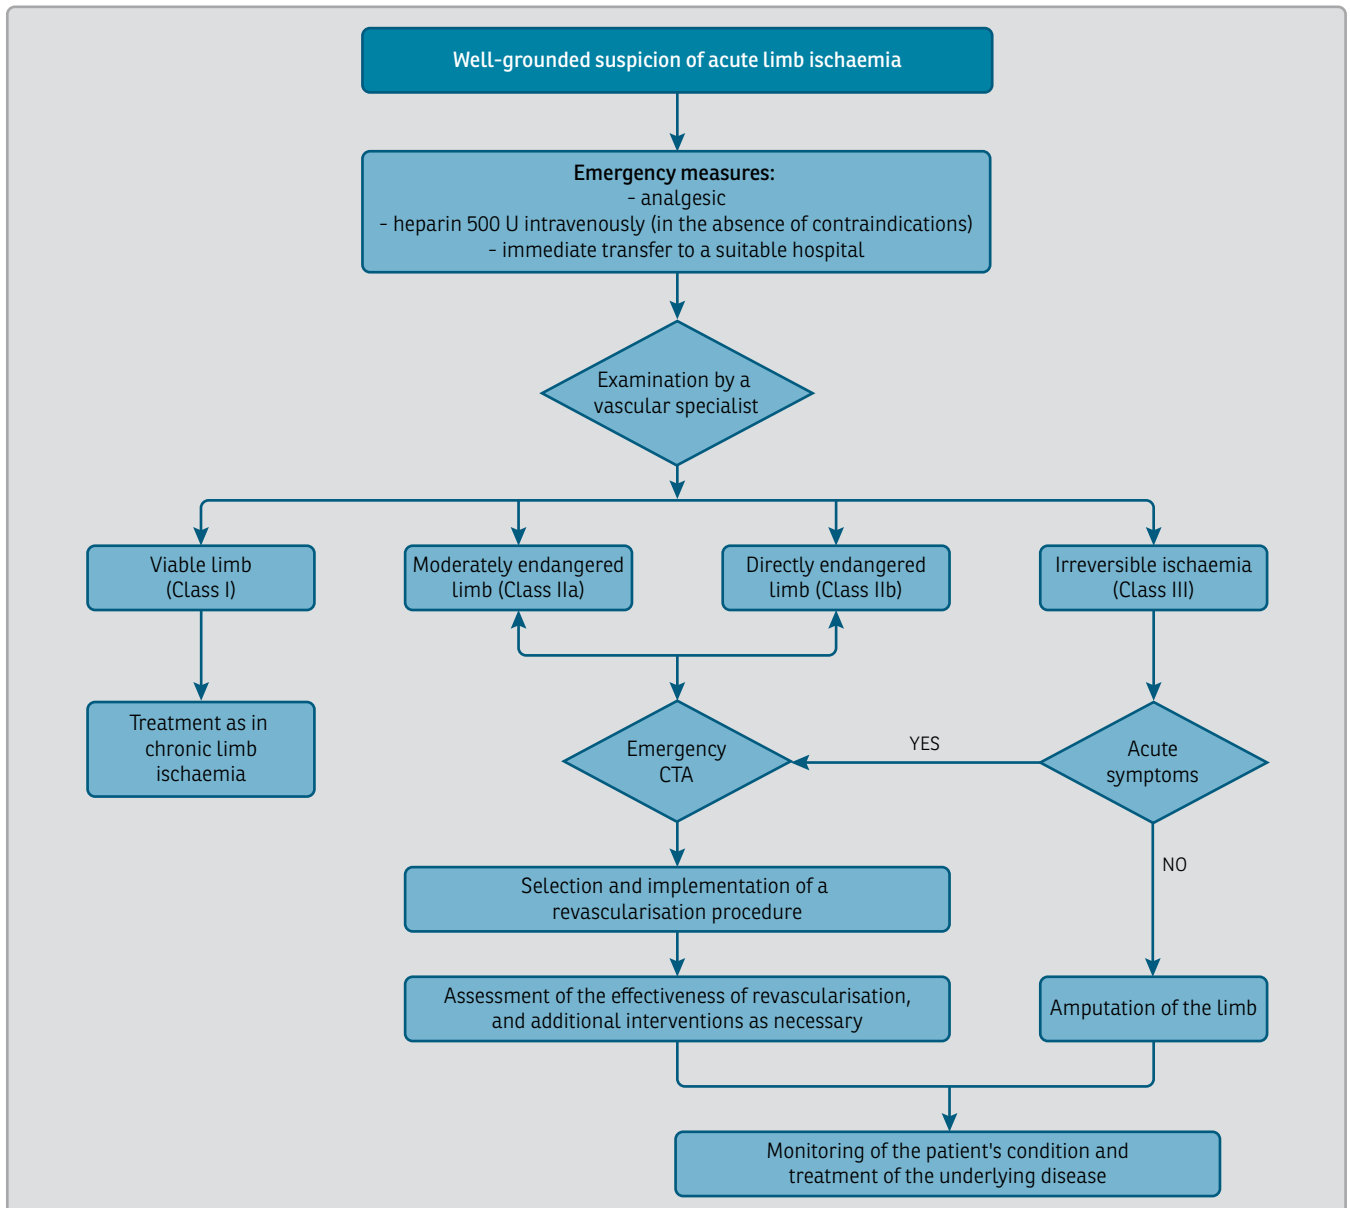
Algorithm of acute limb ischaemia management. CTA computed-tomography angiography. Adapted from 1.
